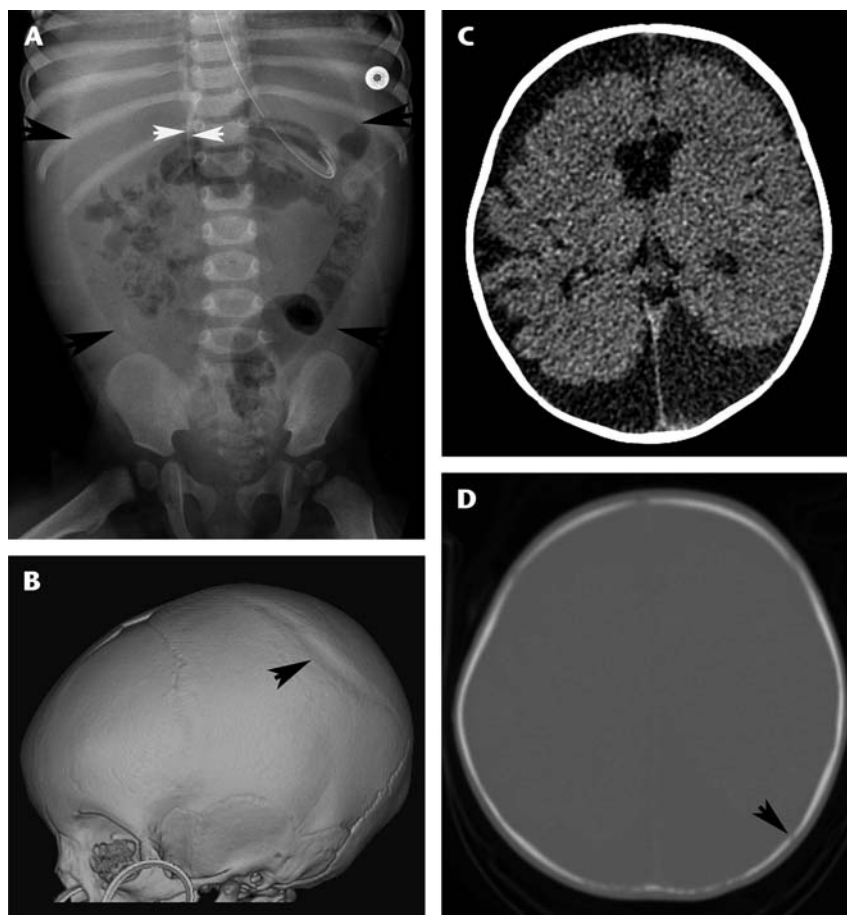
A, An 8-month-old female infant had free intraperitoneal air (black arrows), highlighting the falciform ligament (white arrows) from a gastric rupture. B, 3-D CT calvarial reconstructions show healing biparietal skull fractures (arrows). C and D, Previous CT performed for macrocephaly when patient was 3 months of age shows prominent extra-axial spaces (C), and in retrospect a subtle left parietal fracture that had been missed (arrows) on axial bone windows (D).
